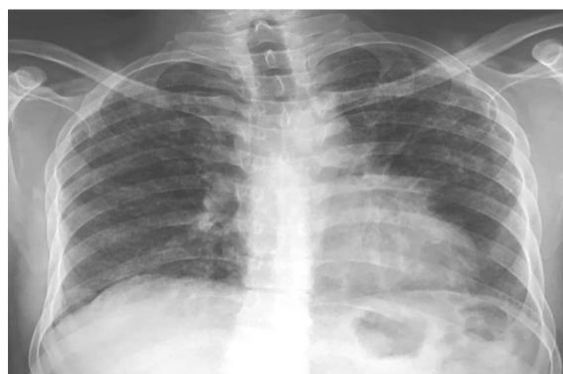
Chest X-Ray postero-anterior shows diffuse, ill-defined haziness, predominantly in lower lobes
